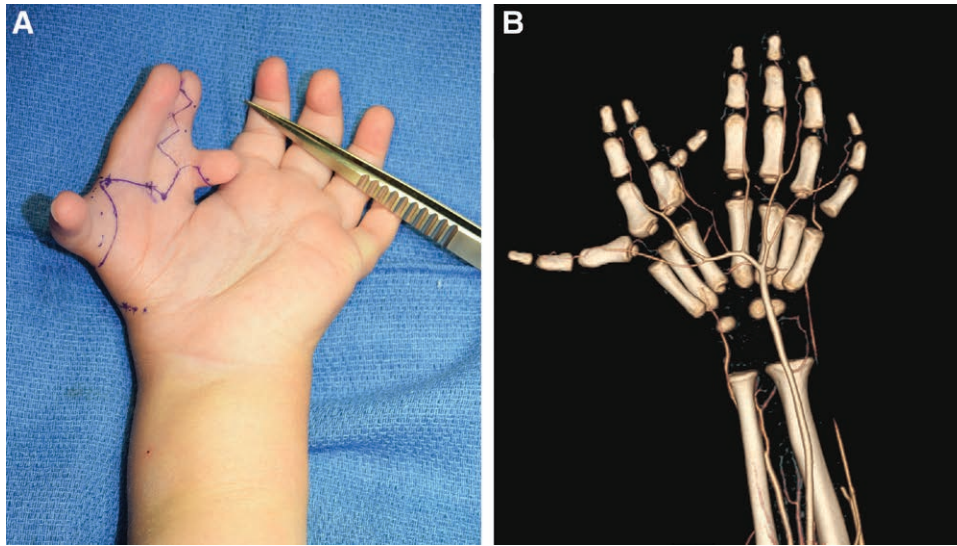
Preoperative image (A) and computed tomography bony and vascular imaging of the deformity (B).
